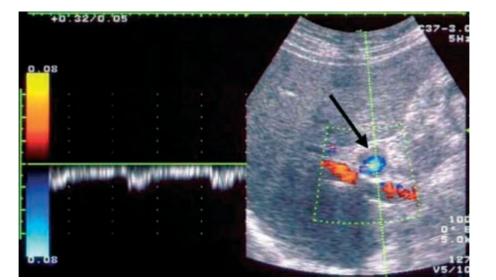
(Patient 1): Pulsed-colour-Doppler ultrasound through the liver hilum showing a cross section of a dilated vessel with mural thrombus and arterial signal (arrow).
